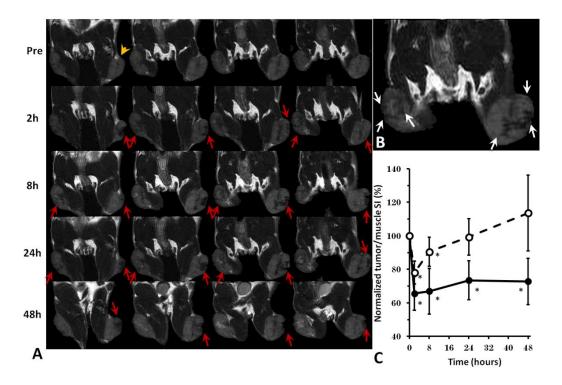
In vivo* longitudinal MRI at 9.4T of exposed PS in 4T1 breast tumors following i.v injection of SPIO-PGN635.
